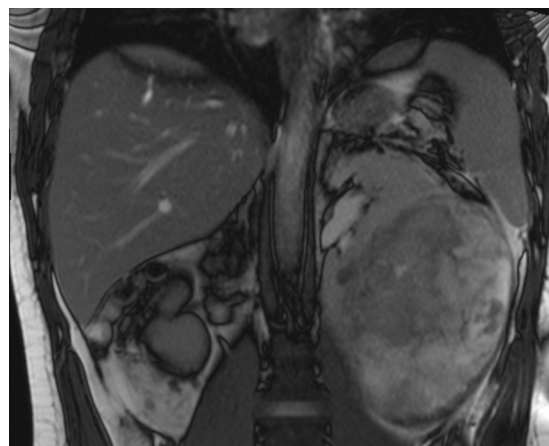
Coronal view of an MRI abdomen showing a large perirenal haematoma compressing the renal parenchyma.
